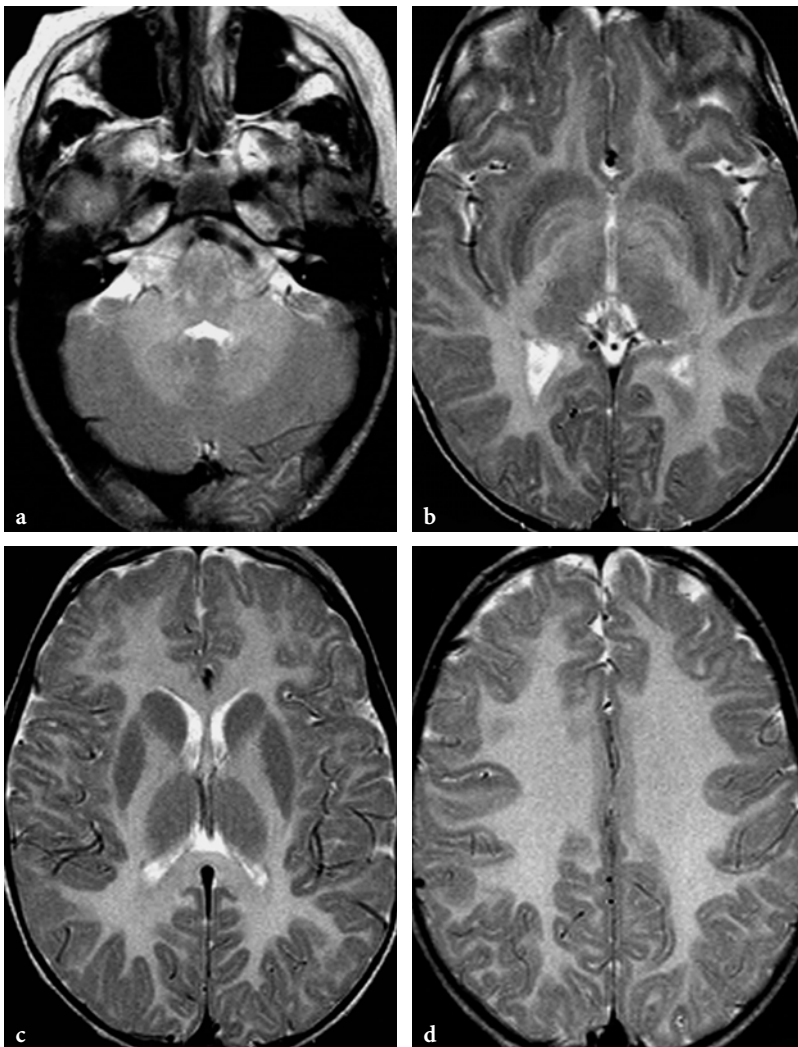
MR imaging findings in a 4-year-old male patient with Pelizaeus-Merzbacher disease (courtesy of Dr. P. Tortori-Donati). a–d Axial T2-weighted fast spin-echo images. Some myelin is suggested within the brainstem, but within the cerebellum and supratentorially all white matter structures are completely unmyelinated
